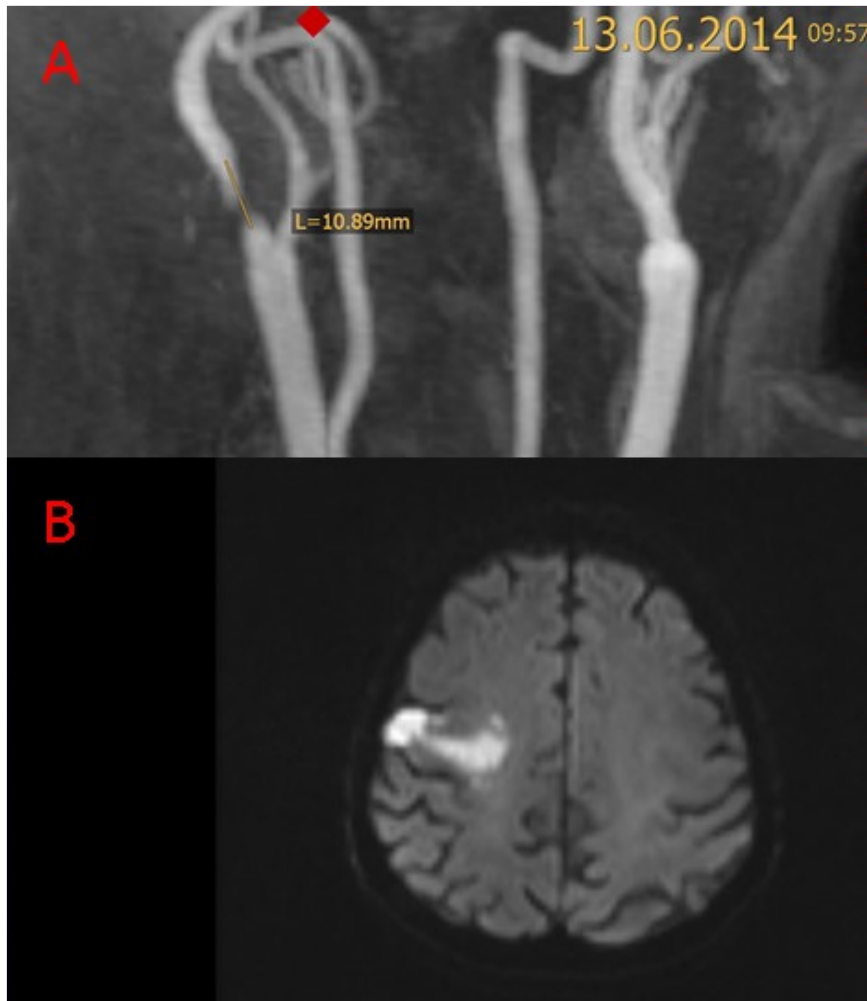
A. MRA (patient 77) showing an ICA stenosis with a length of 11 mm, B. DWI-MRI showing an embolic infarction in the corresponding MCA territory
